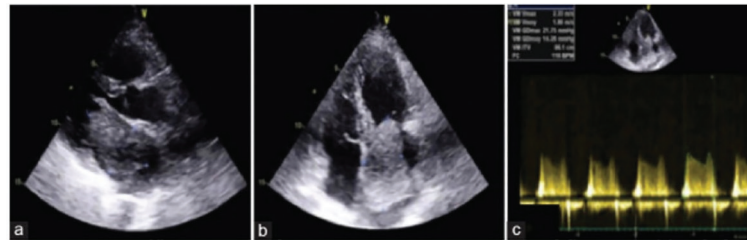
Giant left atrial myxoma in an adult at two-dimensional echocardiogram. A) Parasternal long axis view. B) four-chamber apical view. In both images, the tumor blocks the left ventricular inflow tract. C) Continuous Doppler showing increased mean gradient (14 mmHg) compatible with obstruction.
